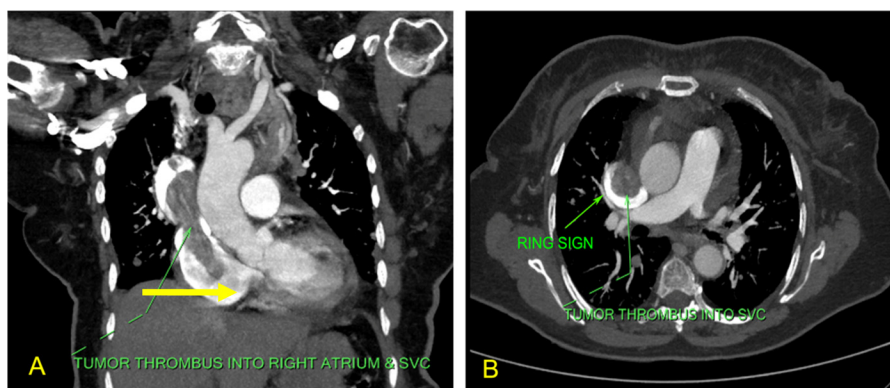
(A) Computed tomography image in coronal view of the thorax showing tumour thrombus extending across the superior vena cava (SVC) into the right atrium. (B) Cross-sectional CT image of the chest showing the tumour thrombus in the SVC with the positive “Ring Sign”.
